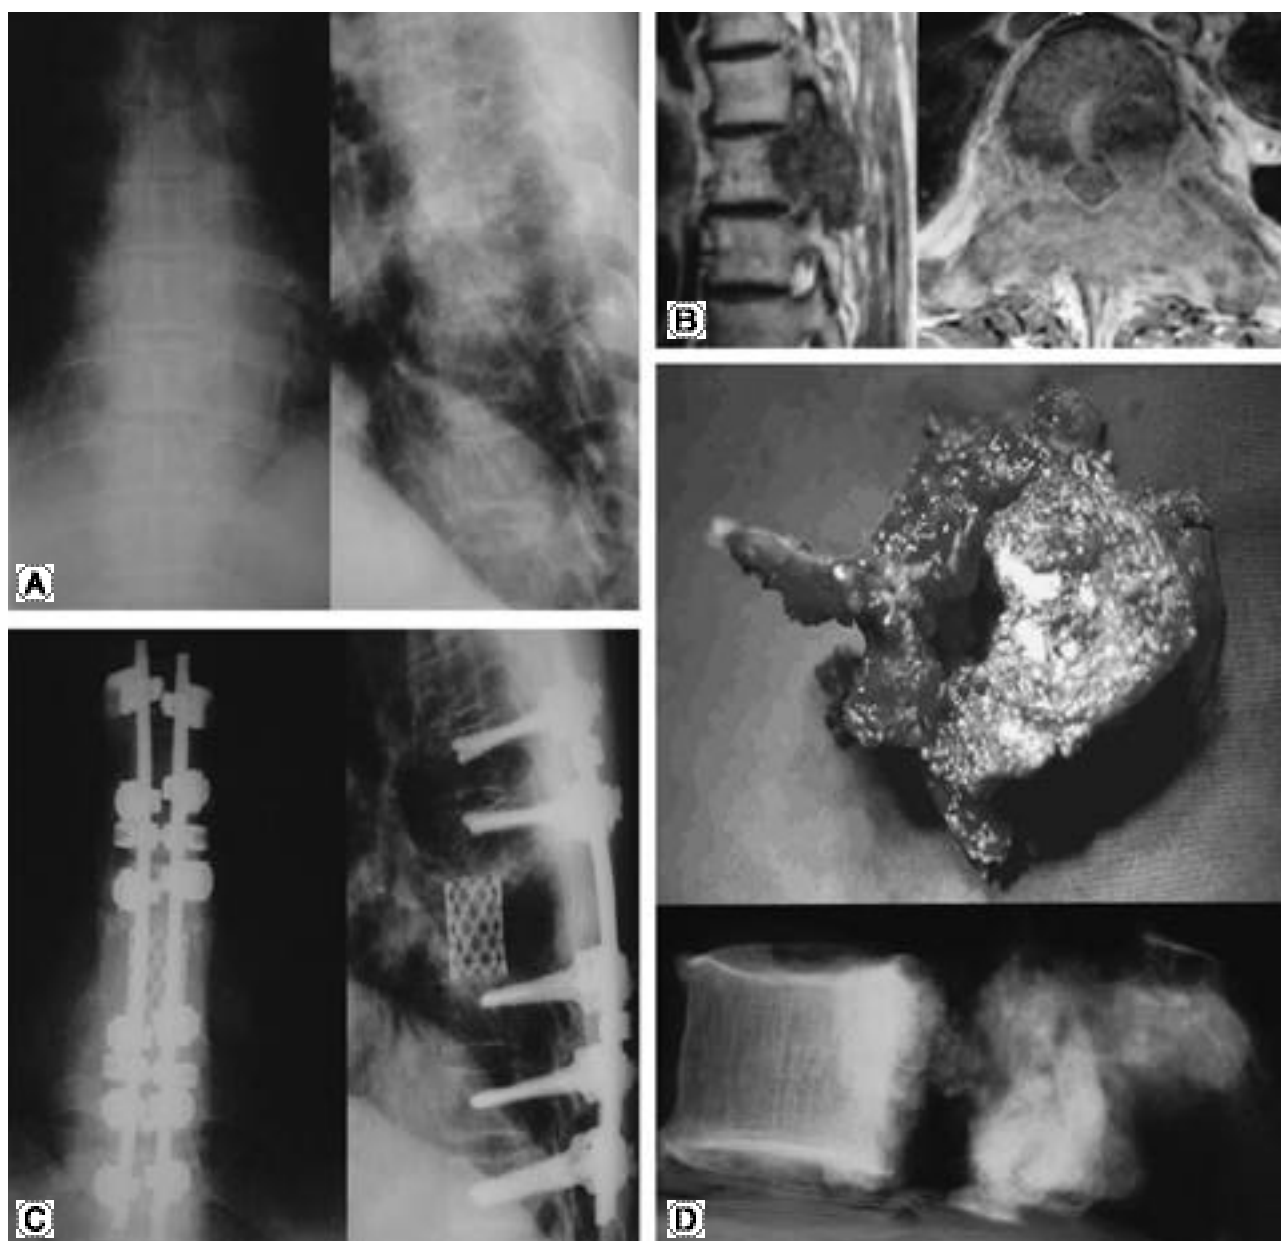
65-year-old man who had a bladder cancer (A) Preoperative radiographs shows destruction of both pedicle of T7. (B) Axial and sagittal MR image demonstrate solitary T7 metastasis and Tomita type 5. (C) Radiographs of 1 year 3 months after operation shows no evidence of local recurrence. (D) Photograph and radiograph of the excised T7 vertebra.
